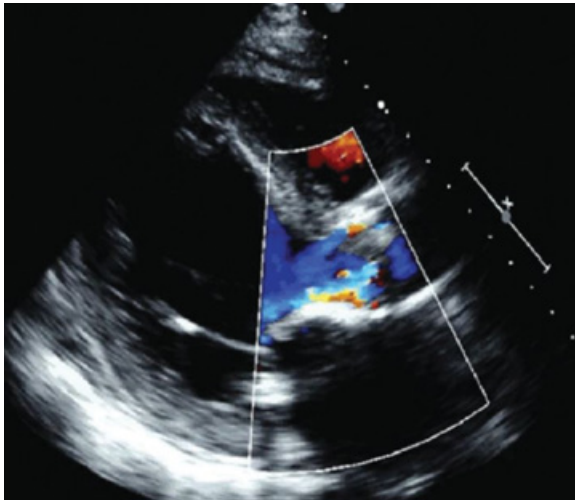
Parasternal long axis view of subvalvular aortic stenosis tunnel type.
